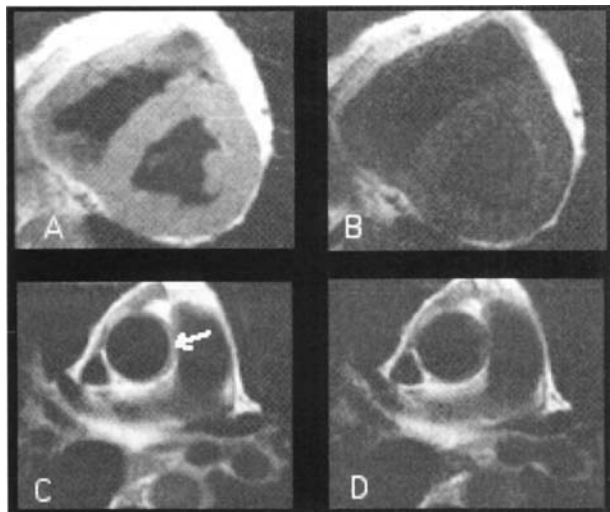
(A) Black-blood proton density weighted image of the heart and (B) the corresponding T2-weighted image. (C) Black-blood proton density weighted image of the aortic vessel and (D) the corresponding T2-weighted image.
